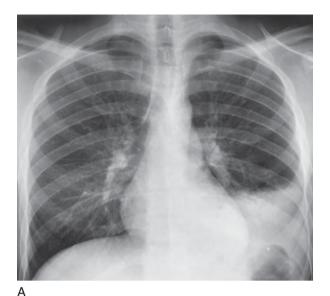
Alveolar pneumonia in the left lower lobe in a 16-year-old boy with fever, chest pain, and cough. Posteroanterior (A) and lateral (B) radiographs demonstrate the typical characteristics of an alveolar process involving the left lower lobe. The infiltrate stands out against the preserved left cardiac silhouette in the posteroanterior projection. (It is posterior to the heart.) It silhouettes the diaphragm in both the posteroanterior and lateral views.
